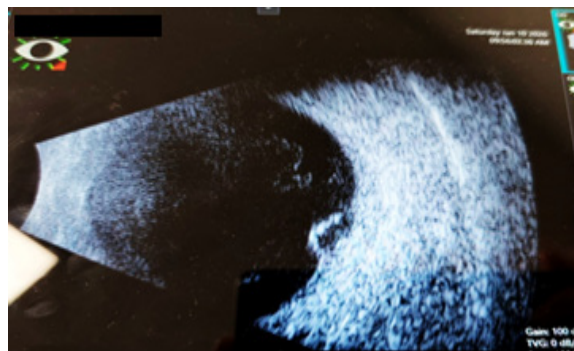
Ocular Ultrasound Showing a Tumor with Hypoechoic Content Compatible with Serous Detachment
